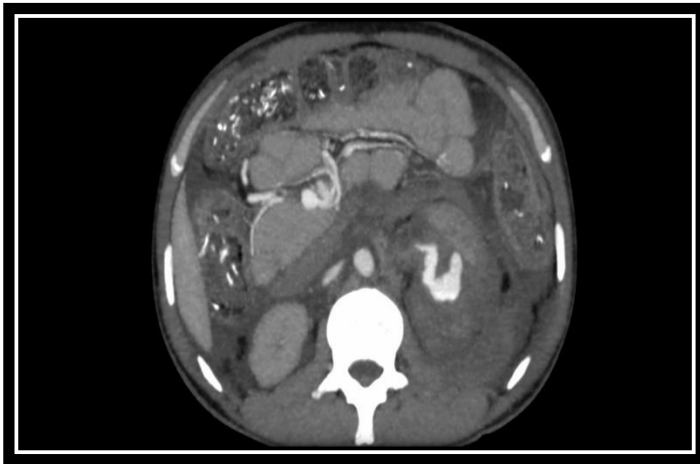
CT scan abdomen with contrast showed pseudoaneurysm formation and large hematoma extending down upto iliac fossa region.
